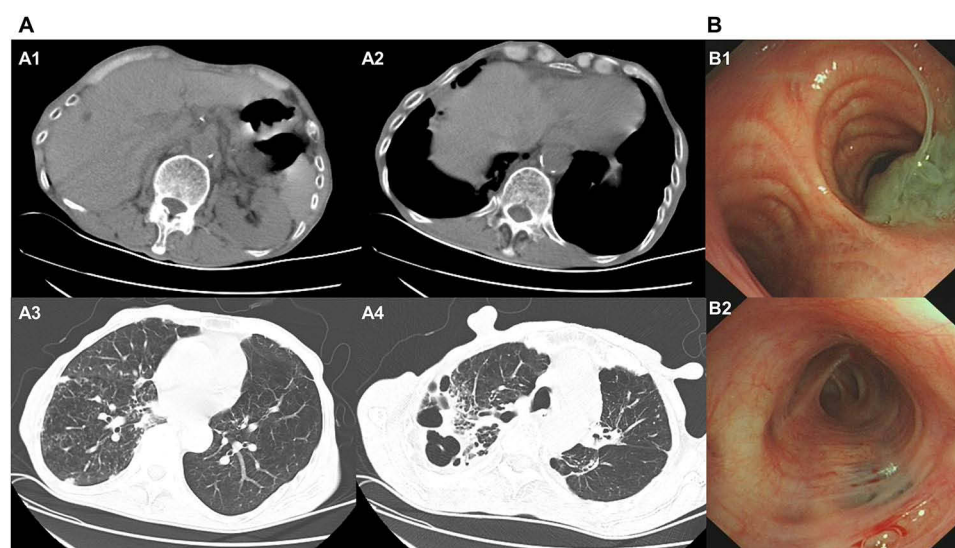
(A) Chest CT examination. (A1) No obvious abnormalities were observed. (A2) Subpleural nodular shadows. (A3) Emphysema was found in both lower lungs, with a small amount of patchy increased density in the right lower lung, accompanied by subpleural small nodular shadows. (A4) Increased and disordered pulmonary markings; patchy consolidations in the upper lobes of both lungs with multiple cavitations, accompanied by surrounding cord-like high-density opacities, pleural adhesion, and thickening. (B) Bronchoscopy examination. (B1) A large amount of purulent and viscous secretions blocked the tube orifice. (B2) Carbon deposition was present.
